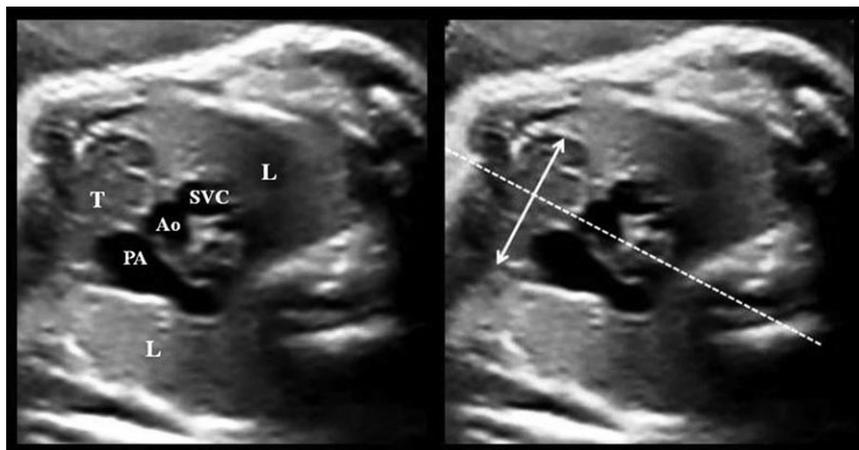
Transverse sonogram of the fetal thorax (30 weeks gestation) without (left) and with (right) the measurement of the transverse diameter of the thymus (double arrow). Abbreviations: Ao, aorta; L, lung; PA, pulmonary artery; SVC, superior vena cava; T, thymus.
